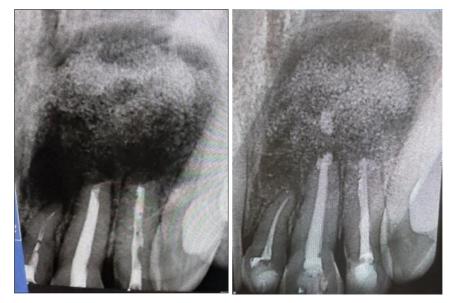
(a): Immediate post-operative radiograph Fig 4(b): 6 months follow-up radiograph
